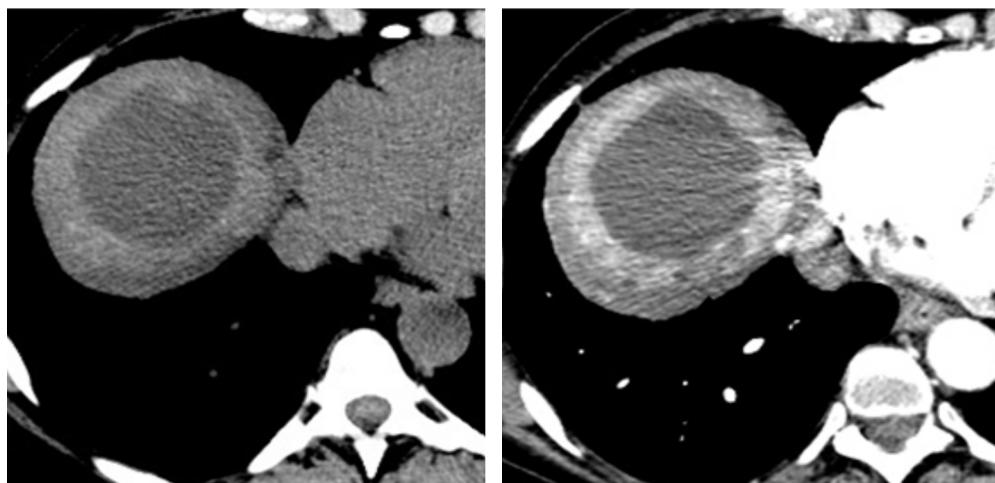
Biliary cyst with superinfection. Computed tomography (CT) with IV contrast shows a thickened cyst wall (left) that enhances with contrast injection (right).
